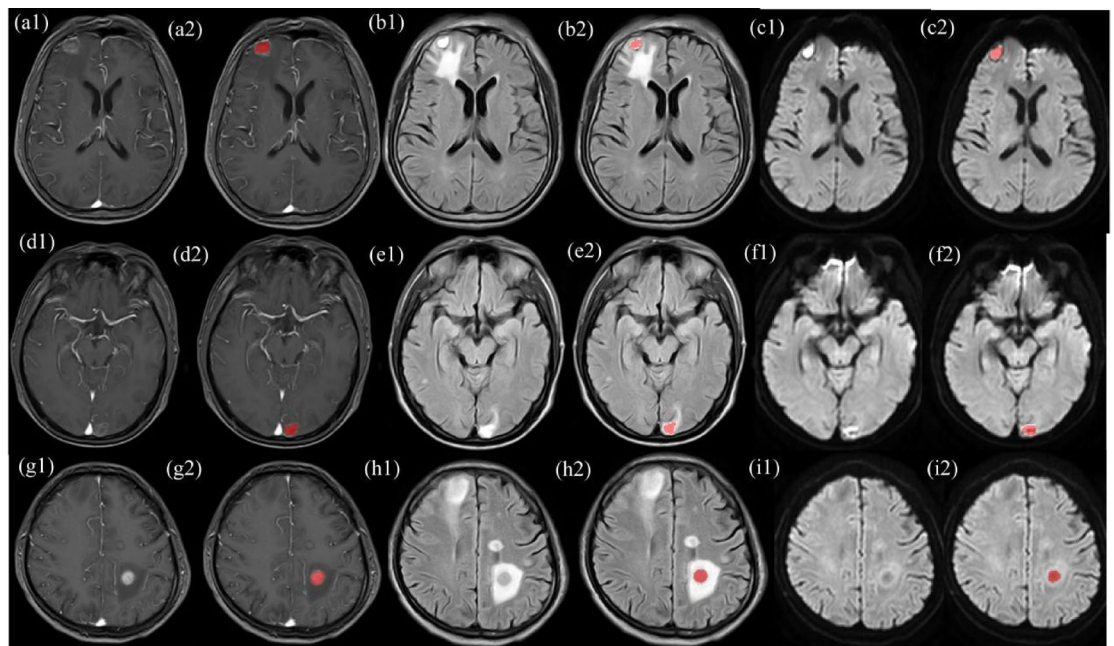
Delineation of ROIs in T1-weighted imaging (T1WI) (a1–2, d1–2, g1–2), T2-fluid-attenuated inversion recovery (T2-FLAIR) ($b = 800$) (b1–2, e1–2, h1–2), and diffusion-weighted imaging (DWI) (c1–2, f1–2, i1–2). a1–2, b1–2, c1–2: man, 66 years old, with BMs in SCLC. a1, b1, and c1 represent the original lesions, and a2, b2, and c2 show the lesions after ROI delineation. d1–2, e1–2, f1–2: man, 45 years old, with BMs in AD. d1, e1, and f1 represent the original lesions, and d2, e2, and f2 depict the lesions after ROI delineation. g1–2, h1–2, i1–2: man, 49 years old, with BMs in NAD. g1, h1, and i1 represent the original lesions, and g2, h2, and i2 display the lesions after ROI delineation.
